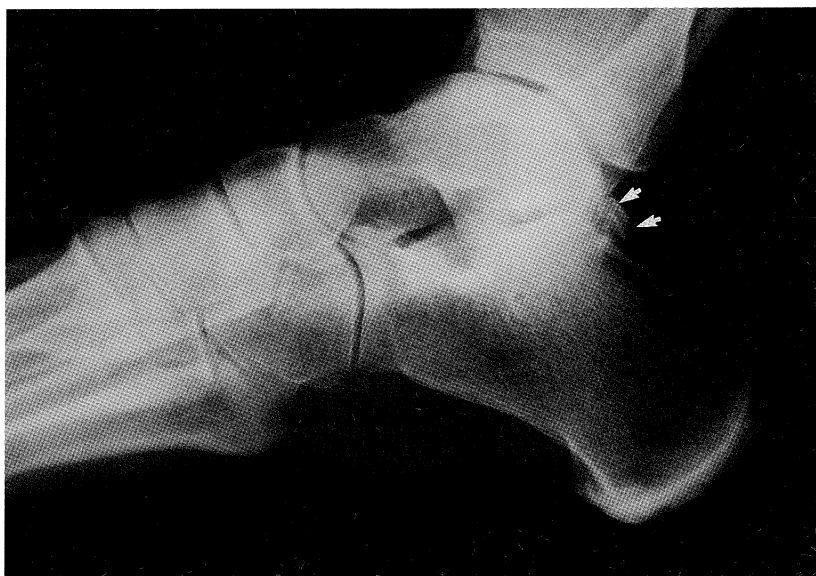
Lateral radiograph of the left ankle in another patient. A well-corticated ossific density (arrows) is seen posterior to the talus. It represents either an os trigonum or a chronic avulsed fracture of the trigonal process of the talus.
